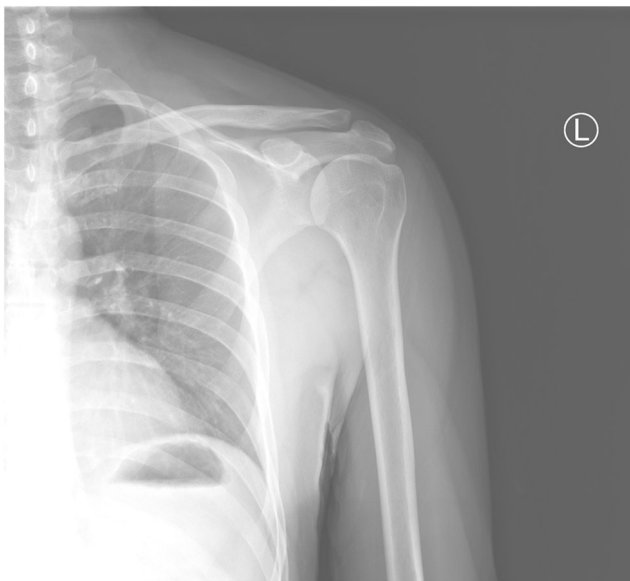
X-ray of the left shoulder showing no abnormality of the clavicle, scapula, and left shoulder
